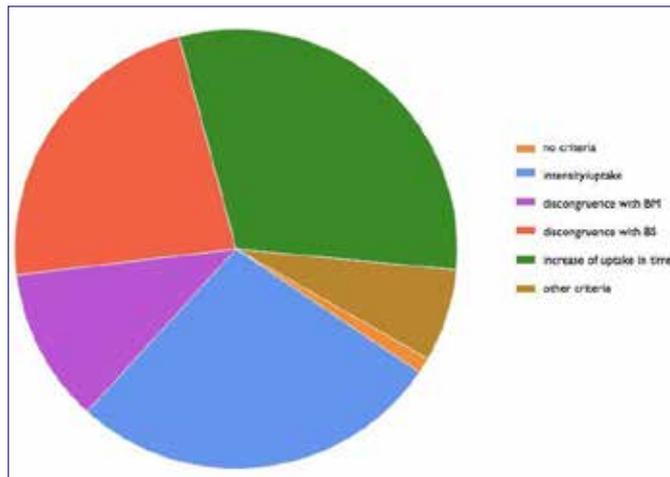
Criteria used for evaluation of leukocyte scintigraphy and LeucoScan BS- bone scintigraphy; BM- bone marrow scintigraphy
